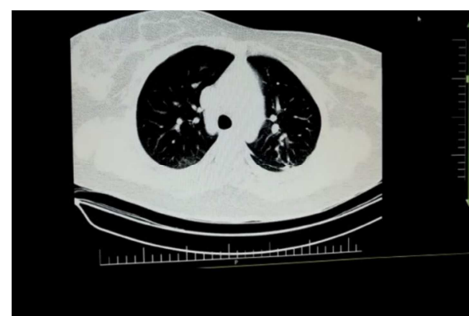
maternal HRCT of neonate case 7, with suspicious peripheral ground-glass appearance.
